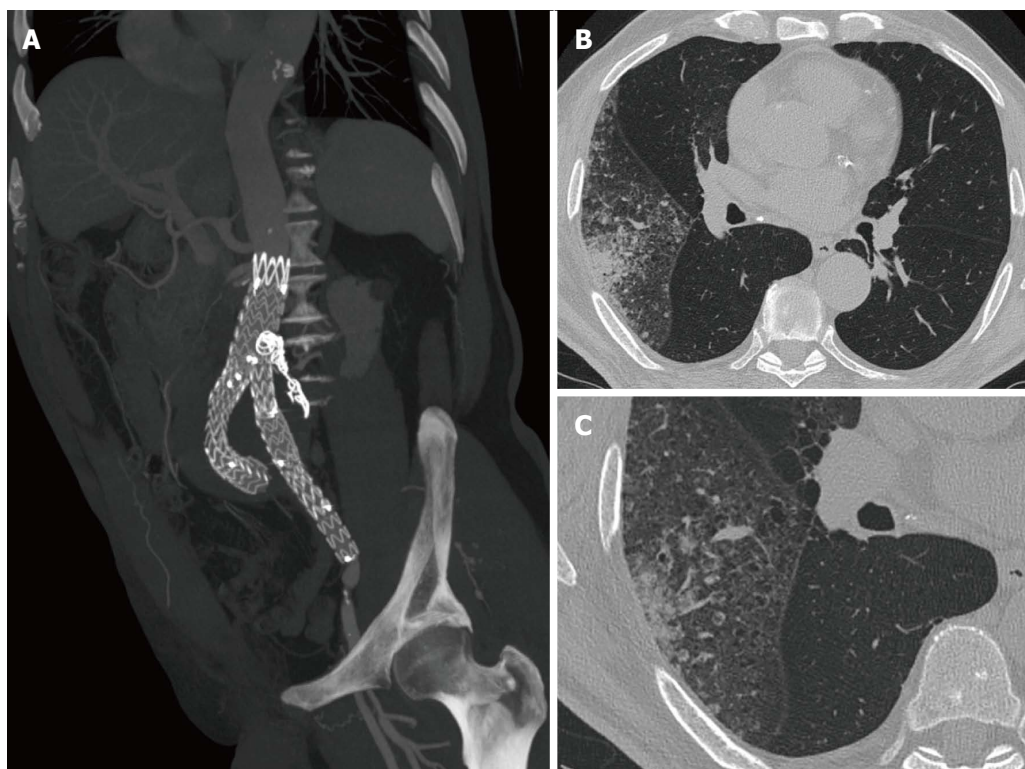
Lepidic predominant adenocarcinoma diagnosed during endovascular aortic aneurysm repair follow-up. A-C: A 80-year-old male with a LPA of the right upper lobe diagnosed during endovascular aortic aneurysm repair follow-up for a type II endoleak treated with glue and coils (A). HRCT images (B and C) demonstrate the lepidic growth of the tumor and aerogenous metastases in the same lobe. LPA: Lepidic predominant adenocarcinoma; HRCT: High resolution computed tomography.
